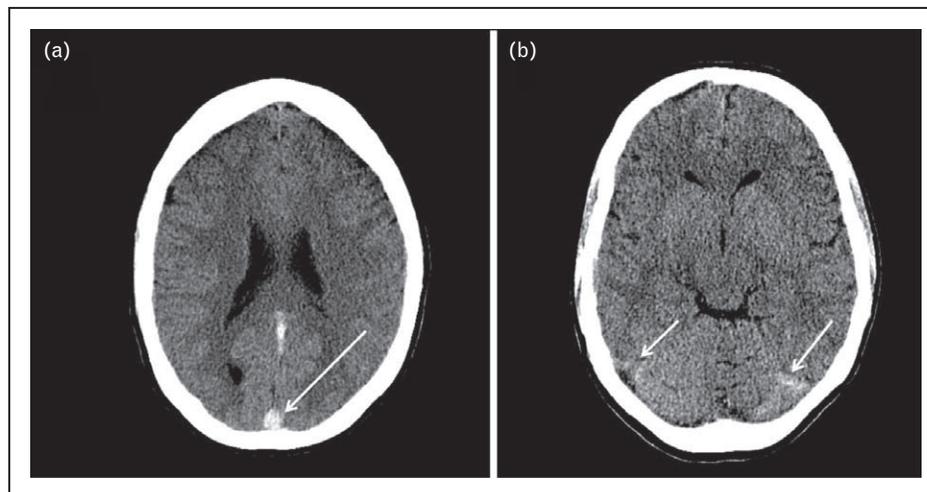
Unenhanced computed tomography brain showing hyperdensity at the confluence of the sinuses (arrow) (a). There are bilateral linear hyperdensities in the parietal lobes (arrows) corresponding to thrombosis of cortical veins (b).
